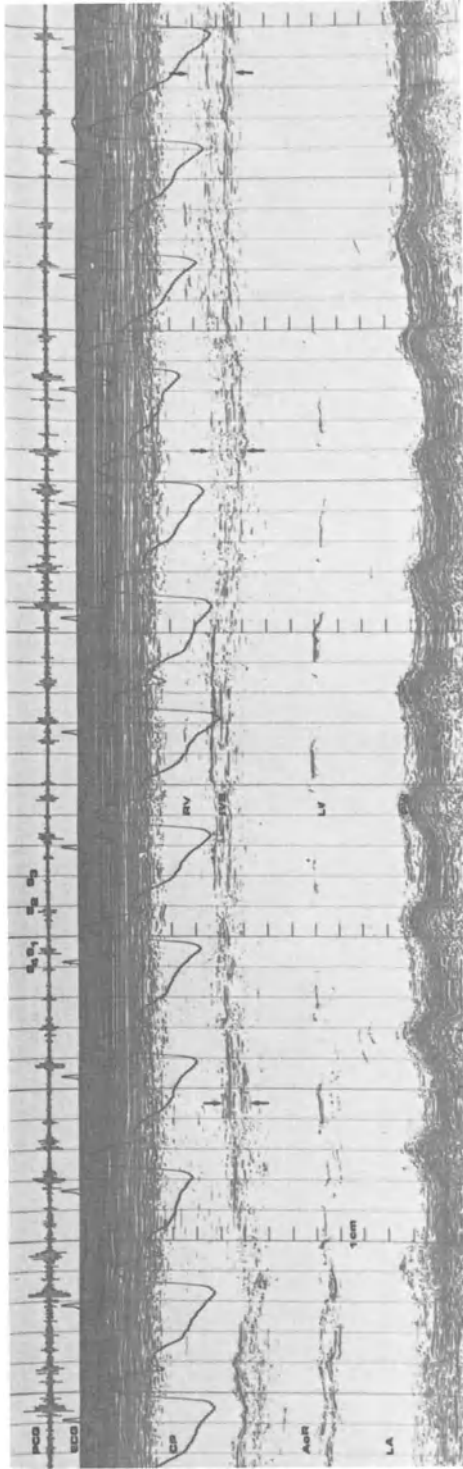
M-mode linear scan echocardiogram recording from a patient with left ventricular aneurysm. Arrows indicate changes in thickness, motion and appearance of adjacent segments of septum.
